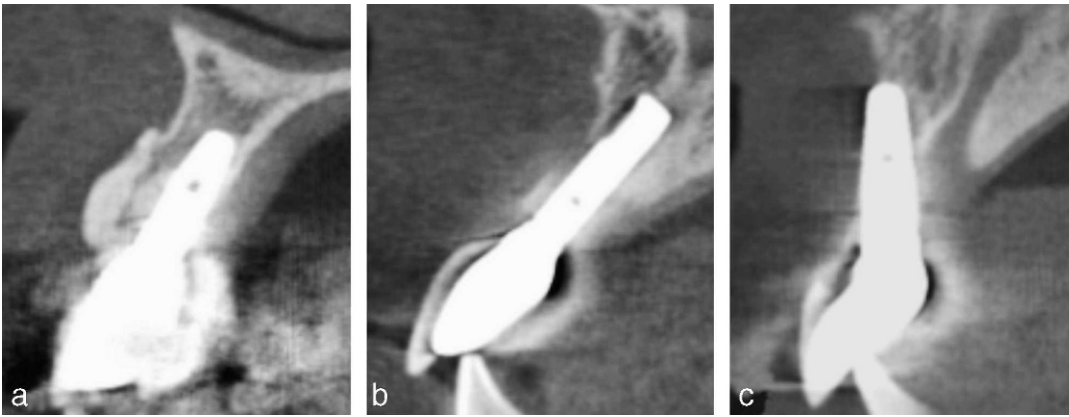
Cross-sectional cone-beam computed tomography (CBCT) images of the maxillary anterior implant. (a) Thick type: the labial bone thickness at the central superoinferior level of the dental implant was 2 mm or more. (b) Hollow type: the labial bone configuration of the central incisor implant was observed as a hollow shape. (c) Resorbed type: the labial bone between the neck and apex of the incisor implant was unclear.
